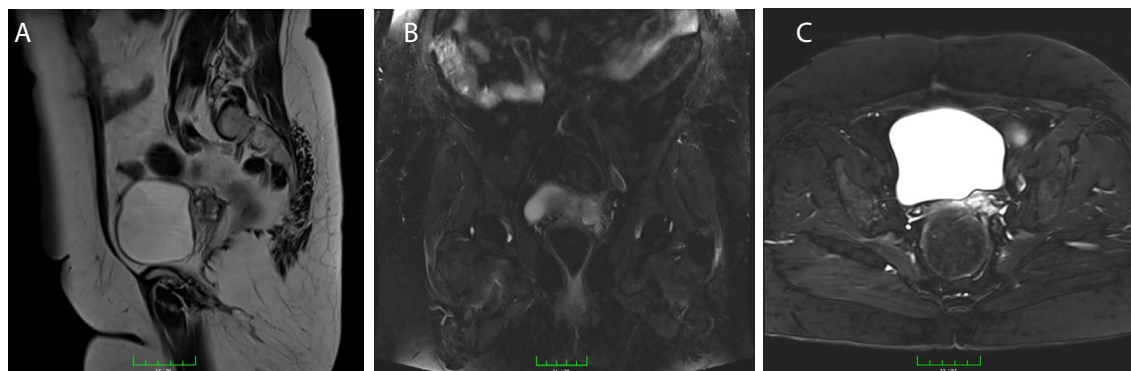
Pelvic MRI showing a 2.4x2x 3 cm recurrent mass about located in recto-vaginal area posterior to left side of the bladder wall (a) sagittal view (b) coronal view (c) axial view.
